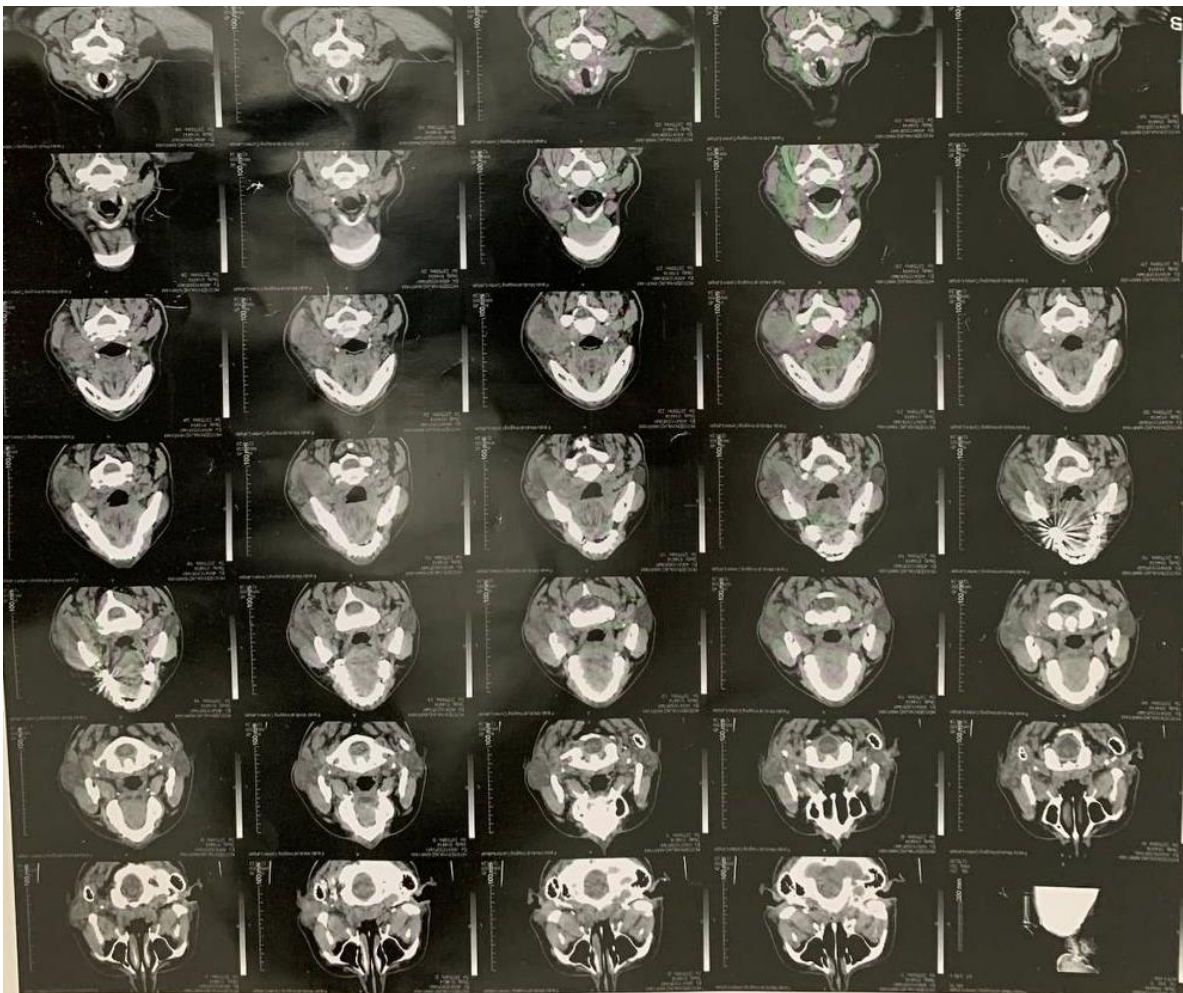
CT scan of parotid glands showing diffuse enlargement of the left parotid gland. Multiple large conglomerated lymphadenopathies were observed which some of these lymphadenopathies showed central hypodensity and peripheral enhancement in favor of central necrosis
